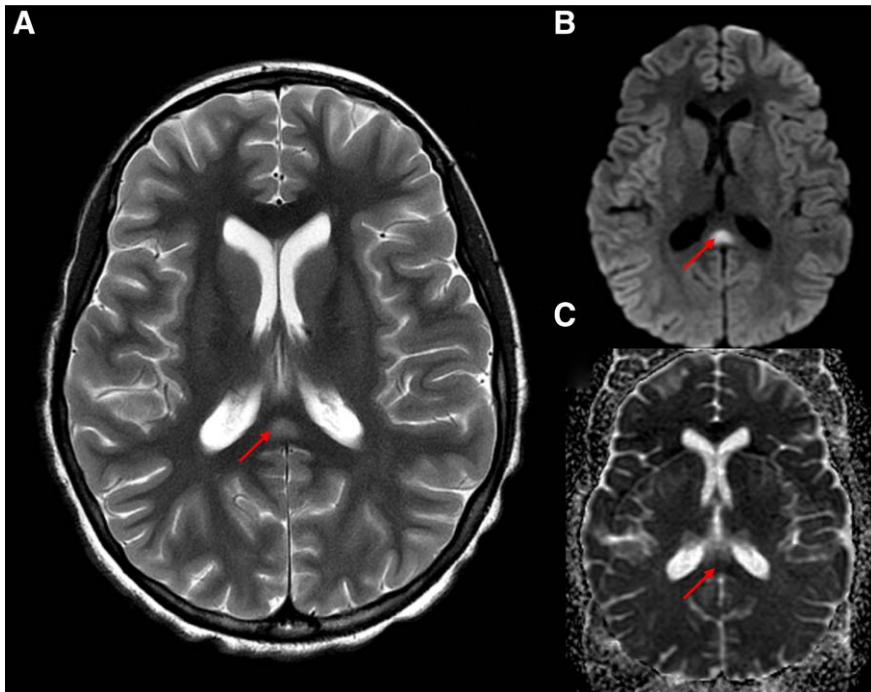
MRI axial images T2 weighted (A), DWI (B) and ADC map (C): oval lesion in the splenium of the corpus callosum (arrow) with T2 hypersignal and diffusion restriction with DWI hypersignal and ADC map hyposignal, corresponding to cytotoxic edema.
